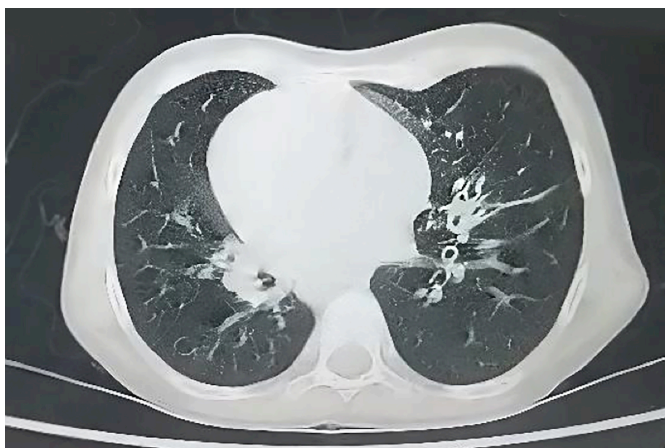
High-resolution computed tomography of chest showing bilateral bronchiectatic changes.
